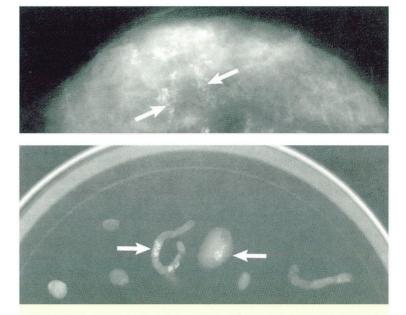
Top, a mammogram with multiple suspicious calcifications for stereotactic biopsy (arrows). Bottom, slightly magnified radiograph of core samples of a stereotactic breast biopsy. The arrows show multiple calcifications in the tissue samples.
